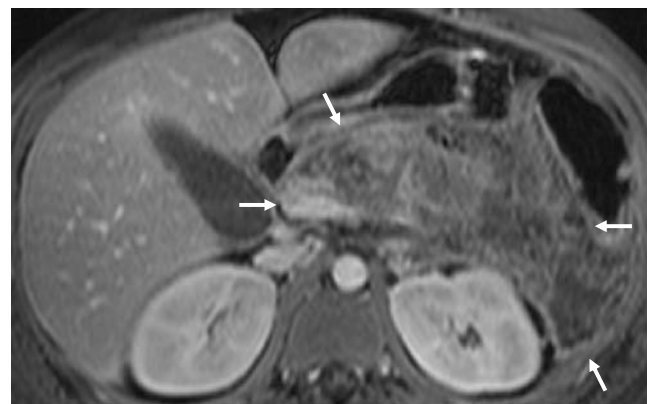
MRI of acute necrotizing pancreatitis. Post-contrast T1-weighted sequence with fat saturation shows the massive swelling and then non-enhancing parts of the pancreas
